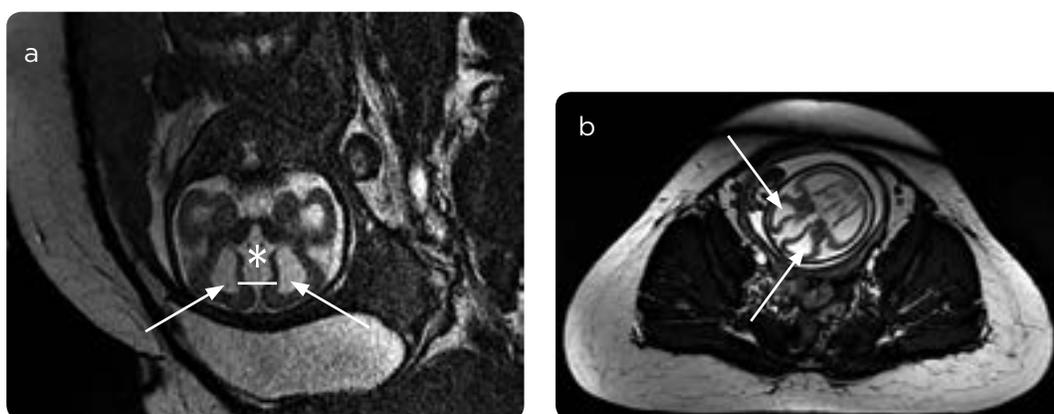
Sagittal pelvic MRI. Patient in pregnancy of 28 weeks of gestation. a) Sagittal acquisition with T2 information: absence of corpus callosum (\*), ectasia of the lateral ventricles (arrows), diastasis of the interhemispheric space (-). b) Axial pelvic MR: colpocephaly (arrows).
